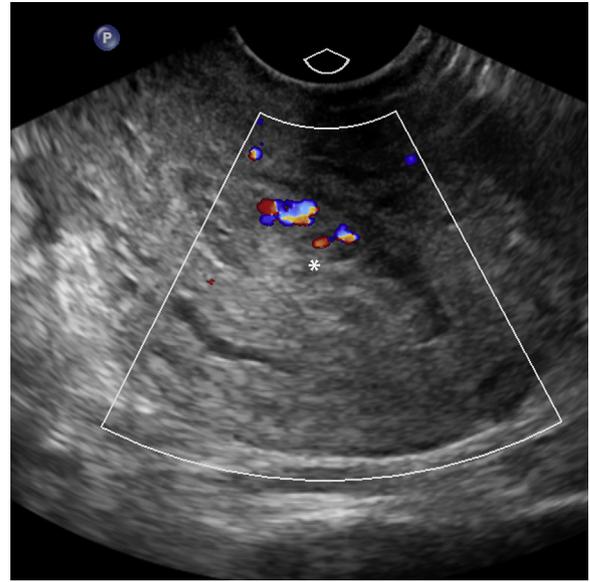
A 22-year-old woman who is 6 days postdilation and curettage for an 8 week pregnancy. She presents with pelvic pain and vaginal discharge with a positive serum beta human chorionic gonadotropin. Transvaginal ultrasound demonstrates retained products of conception with thickening of the endometrial cavity with a heterogeneous mass with colour flow (asterisk). Endometrium measures 18 mm. Patient was treated with repeat dilation and curettage and a course of antibiotics. This figure is available in colour online at <http://carjonline.org/>.
